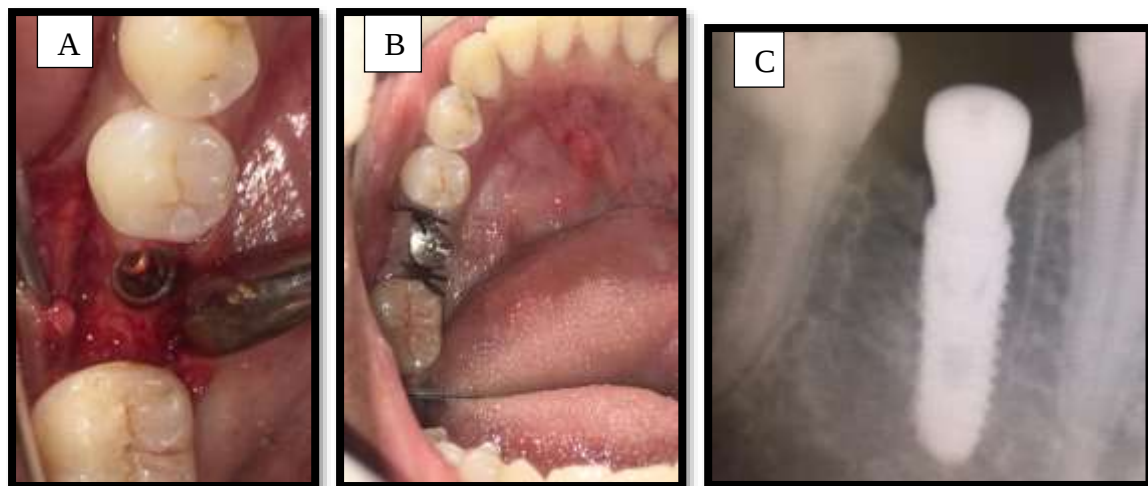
Post-operative Images (A,B) Clinical, (C) Radiographic
